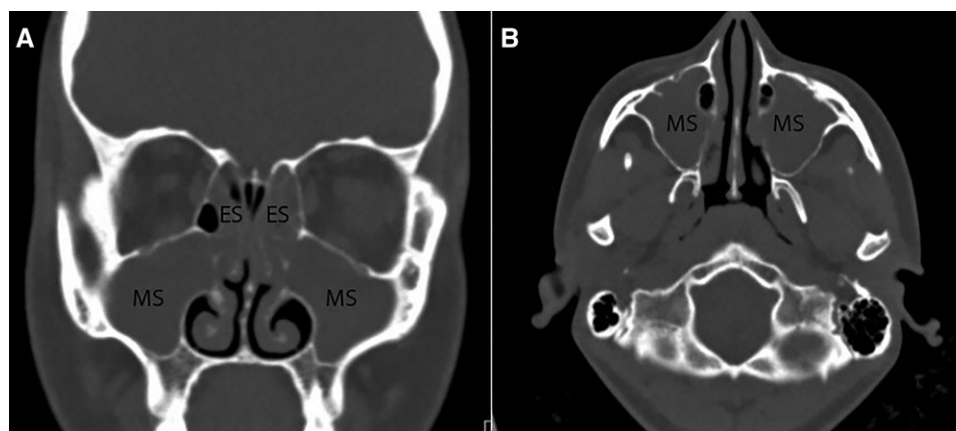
A 20-yr-old professional swimmer reported recurrent transient and increasing left-sided facial nerve palsy during flight. CT revealed chronic rhinosinusitis of the maxillary sinus (MS) and ethmoidal sinus (ES) on the A) axial and B) coronal planes.
